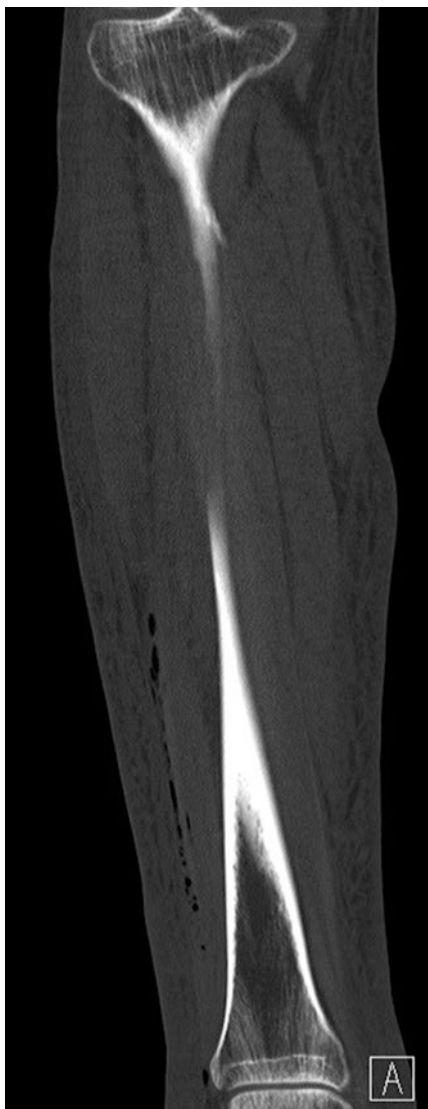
Lateral radiograph of the affected extremity. Again note the extensive air within the tissues posterior to the tibia
